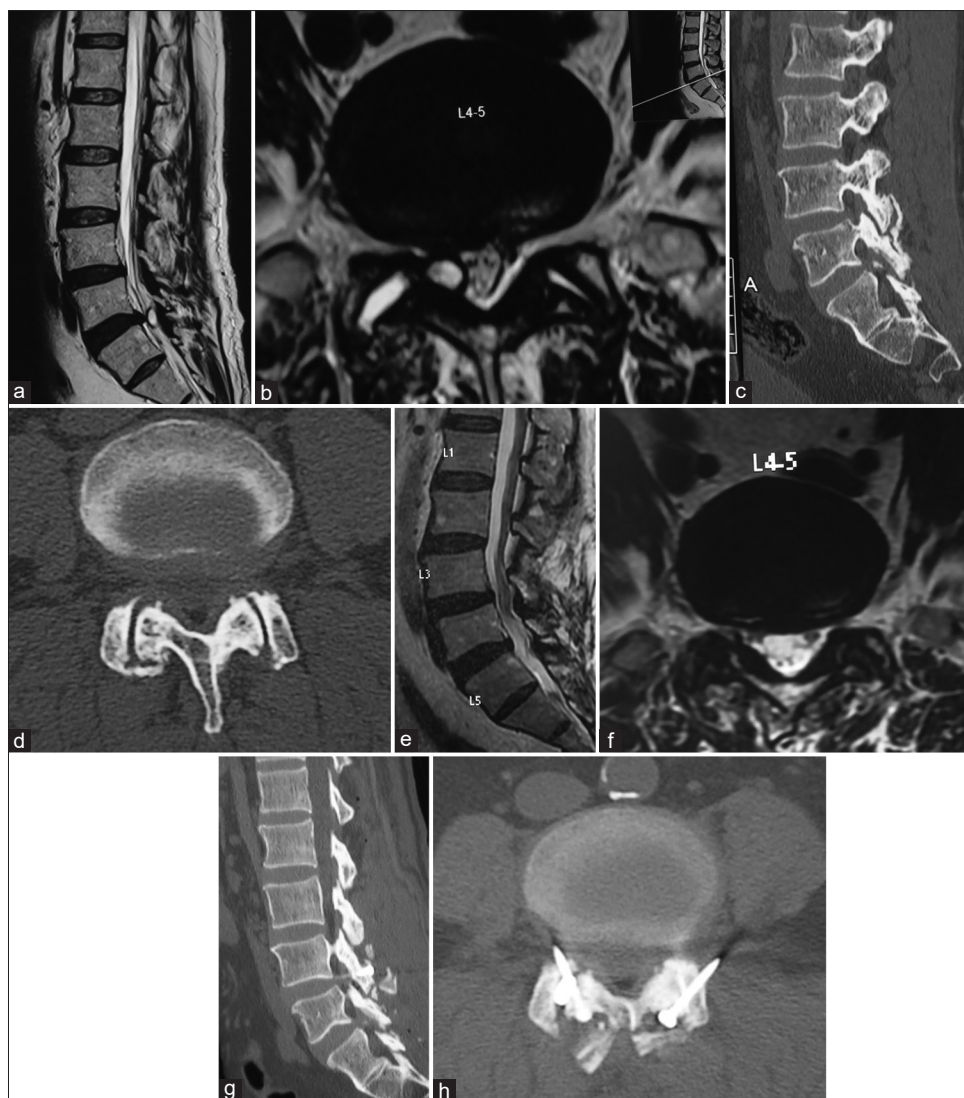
(a) T2-weighted sagittal magnetic resonance imaging (MRI) of the lumbar spine showing the synovial cyst at L4 – L5 level. There is a prominent disc bulge seen at the same level. (b) T2-weighted axial MRI showing the synovial cyst on the right side in juxtaposition to the facet articulation. Also, intra-articular fluid in the right-sided joint is significantly more than on the contralateral side. (c) Sagittal cut of computed tomography (CT) scan showing degenerative changes at L4 – L5 levels. (d) Axial cut of CT scan showing the facet degeneration in the form of multiple facet articulation adjoining osteophytes. (e) T2-weighted sagittal MRI showing the complete regression of the synovial cyst. The disc bulge also appears to have regressed. The canal dimensions are remarkably increased. (f) T2-weighted axial MRI showing complete resolution of the synovial cyst. Facetal arthrodesis can be noted. (g) Sagittal cut of CT scan showing the fixation. No decompression has been done. (h) Axial cut of CT scan showing the facet fixation
